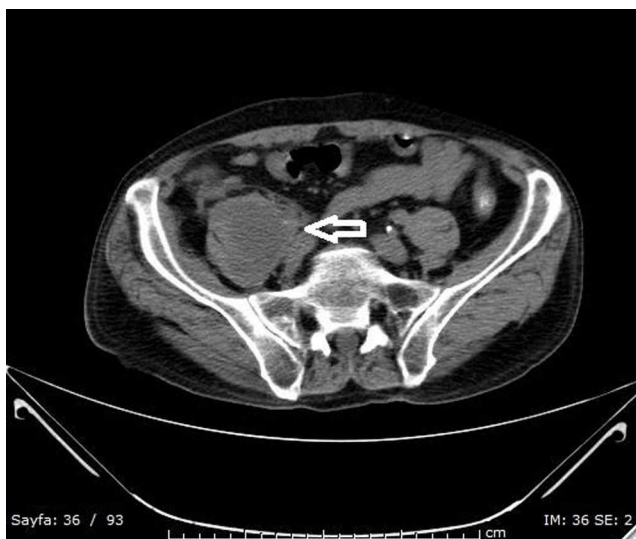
In the axial non-contrast abdominal CT; formation of a hypodense heterogeneous abscess leading to expansion of right psoas muscle which is accompanied by increased densities in the neighboring fatty tissue (hollowarrow).
